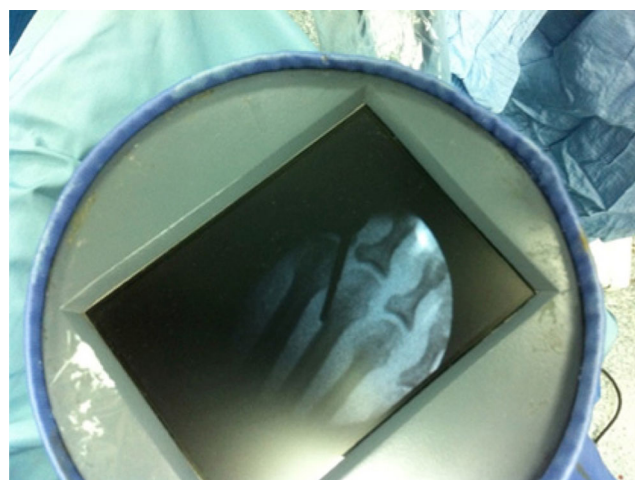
X-ray fluoroscopy mini-amplifier
